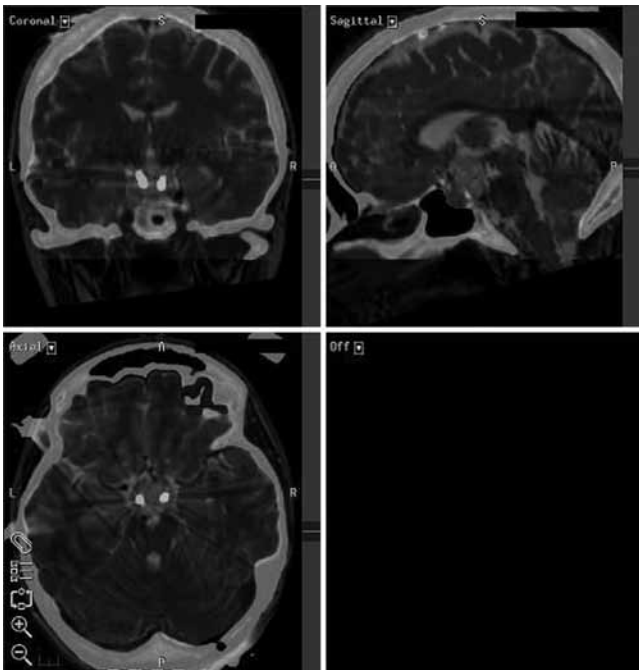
Postoperative brain CT scan merged with preoperative MR imaging (T2-weighted images) showing the position of the electrodes within the malformation.
